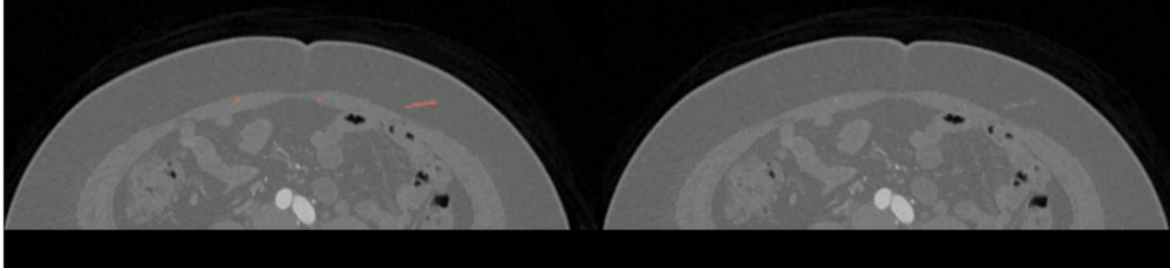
Parallel view in 3D Slicer that was shown to the surgeons during grading the acceptability of manual and automated segmentation of the deep inferior epigastric artery perforators (red) on CTA.
